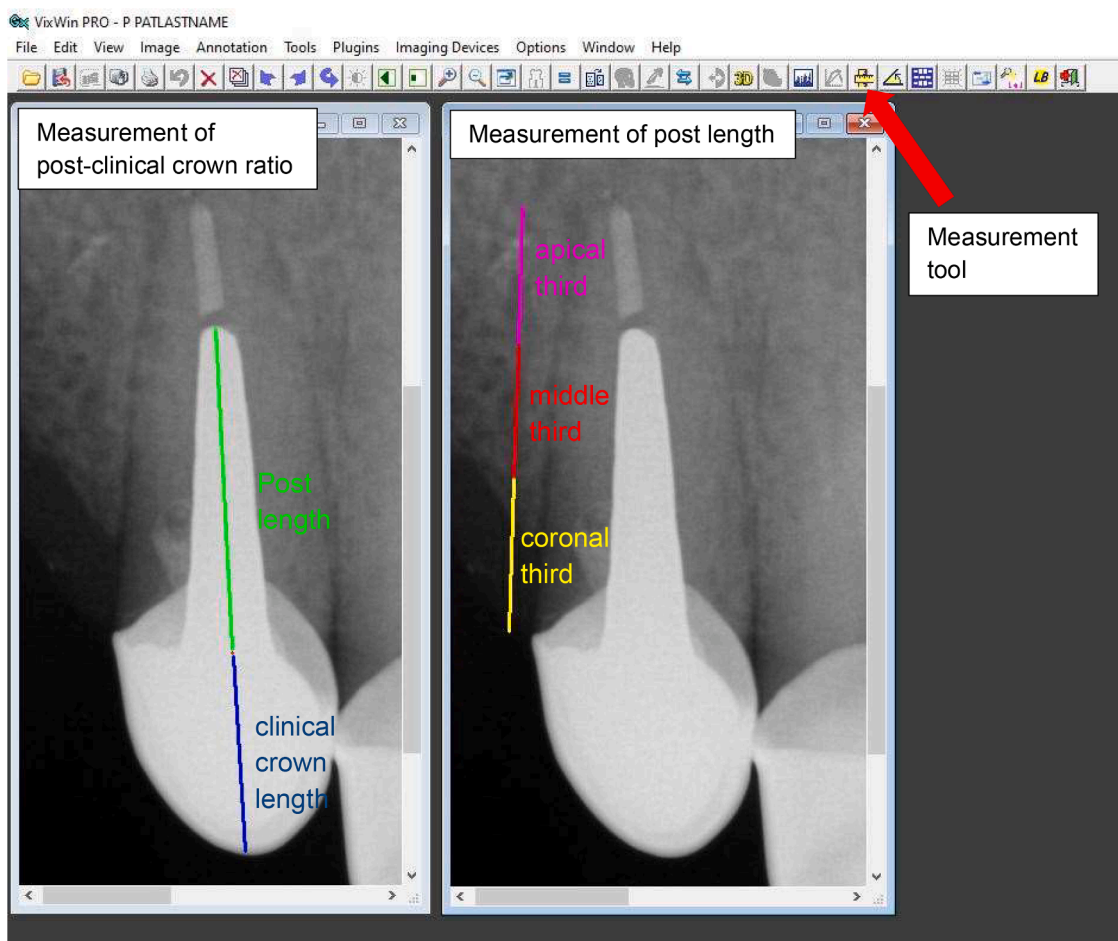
Measurement of post-clinical crown ratio and post length on X-Ray using the measurement tool of an image software.
